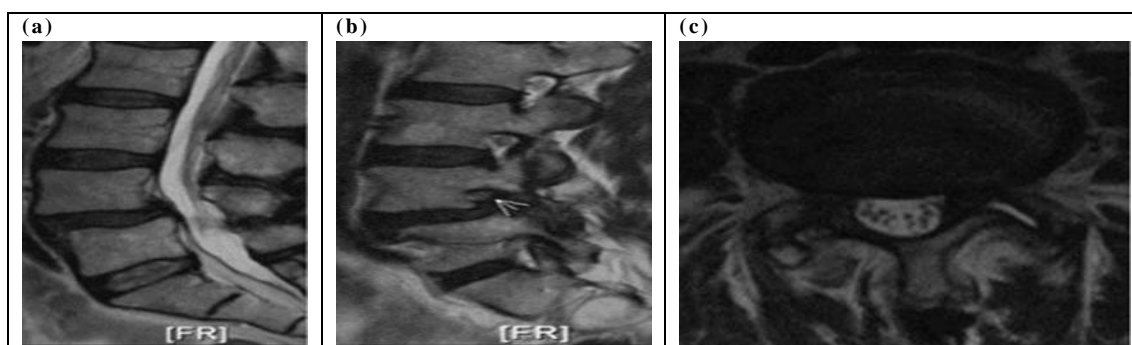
T2-weighted sagittal MRI images of DS at L4-L5 in midsagittal view (A), parasagittal view (B) and axial view at the slip level (C). Foraminal stenosis with diminished fat surrounding the nerve root can be seen (B) (19).
